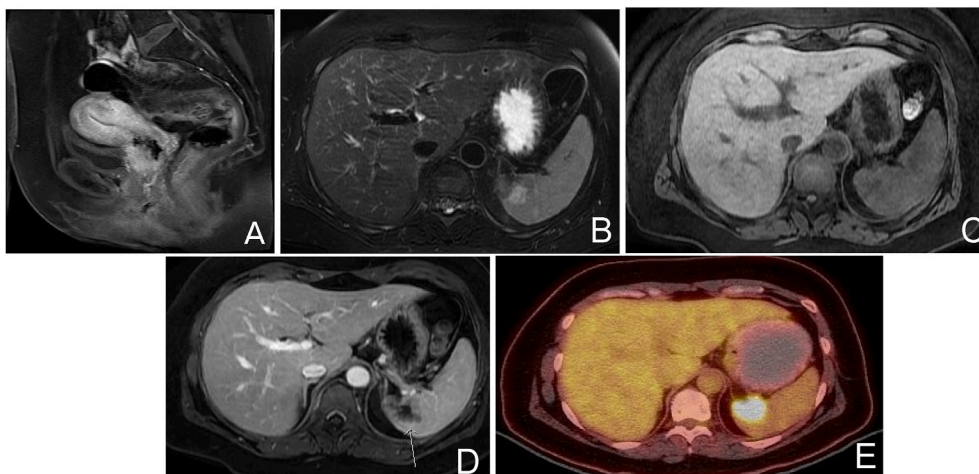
(A) MRI pelvis (T1) post contrast image showing an irregular uterine cervix soft tissue mass involving the anterior of the cervix, extending beyond parametrium borders and protruding anteriorly into the posterior wall of urinary bladder. Follow-up MRI abdomen & pelvis showing a splenic lesion with (B) a central hyper-intensity and peripheral low signal intensity in T2-weighted images, (C & D) low signal intensity in T1-weighted images with peripheral post-contrast enhancement. (E) PET Scan showing FDG avid lesion in the medial part of the spleen.
